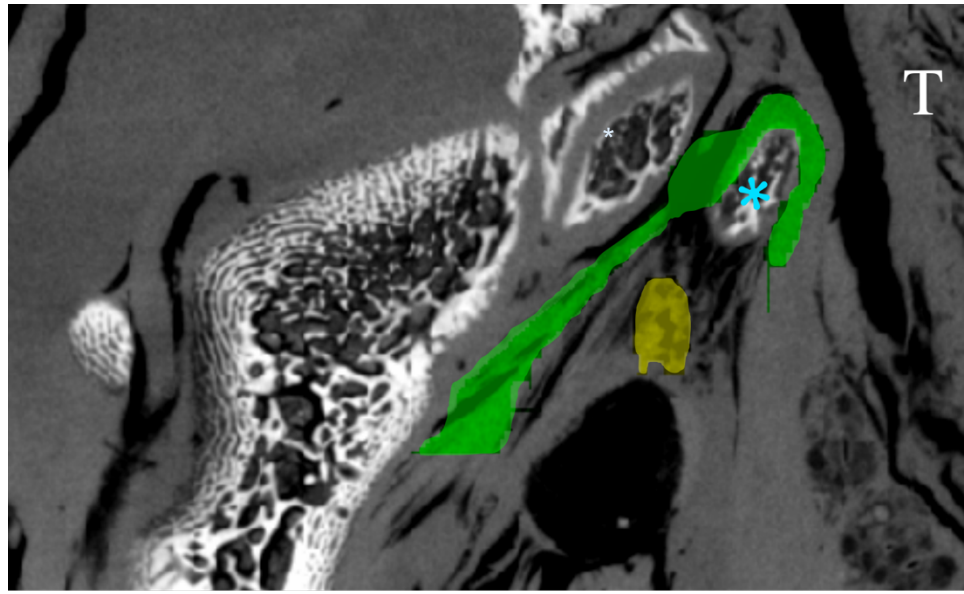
Laboratory-based micro computed tomography image acquired with the Xradia 610 Versa showing the lateral (green) and medial (yellow) heads of the tensor veli palatini muscle around the pterygoid hamulus (*). Note the air inclusions following the muscle fascicles, for instance in the tongue (T).
